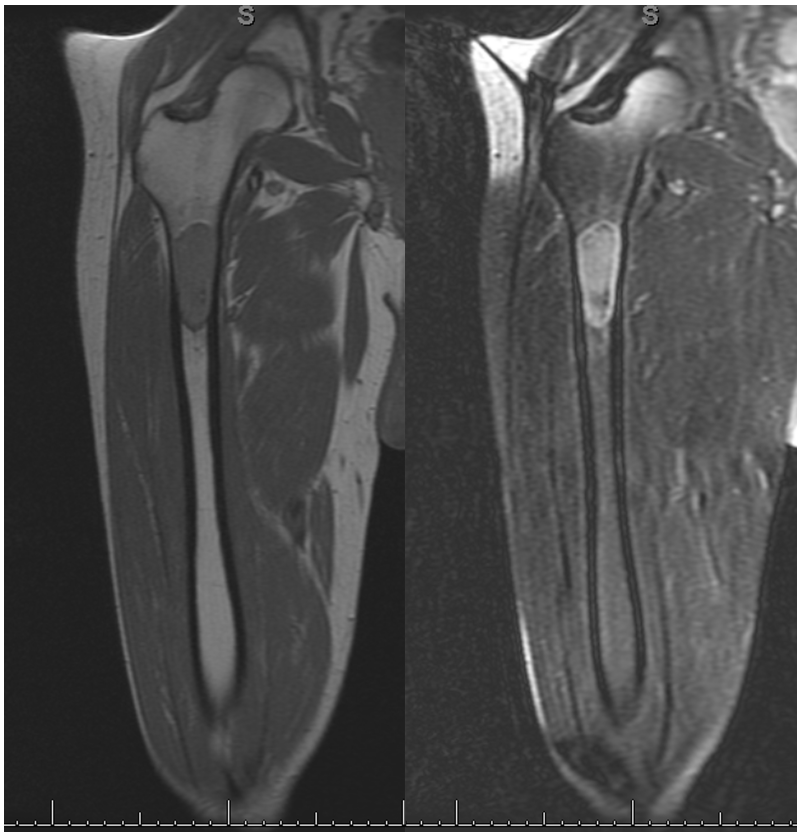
Magnetic resonance imaging (MRI) of right femur showing a subtrochanteric lesion with thinning of the cortices. T1 weighted image (left) and proton density weighted image (right).
